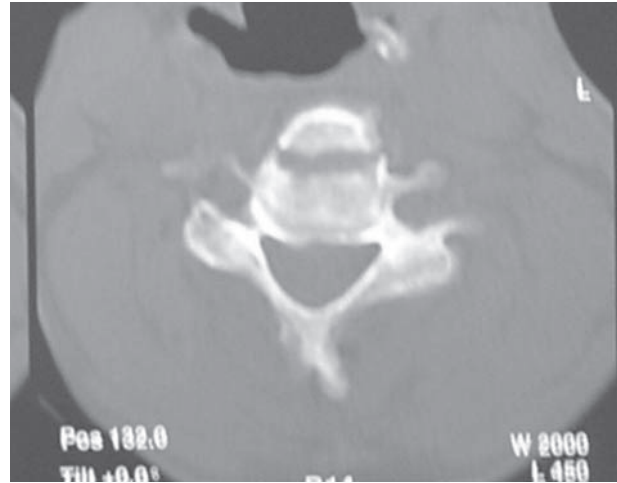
CT showing coronal fracture C4
